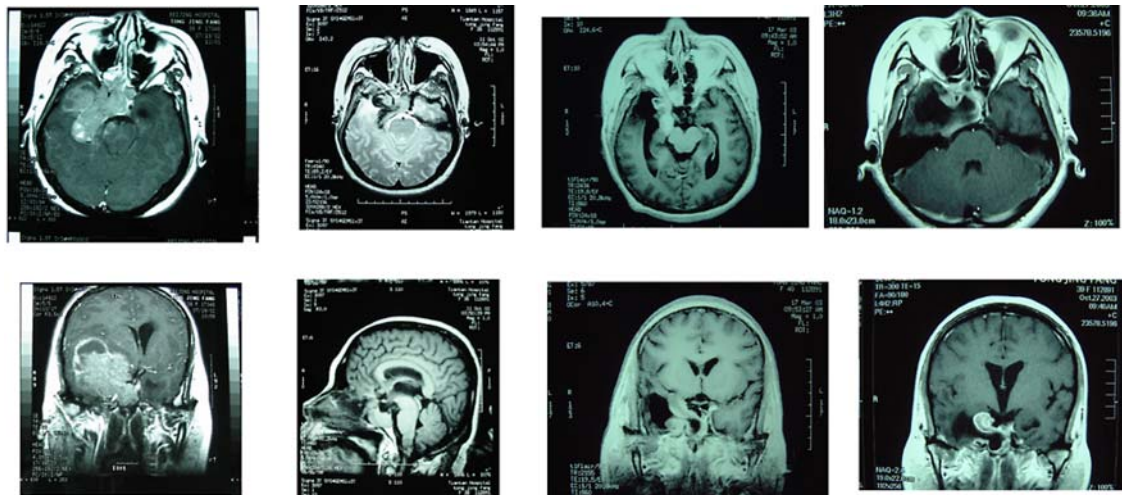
Male, 37 years of age, admitted for visual deterioration of both eyes for one and a half years, vision: L: 0.8, R: 1.5. PRL: >200 ng/ml. MR image before surgery (A, B) Right frontal craniotomy for resection of the tumor. The patient received radiotherapy 2 months after surgery and continued bromocriptine treatment for 4 months after surgery, repeat MR imaging (C, D). 55 months later, repeat MR imaging (E, F) with PRL: 19 ng/ml.
